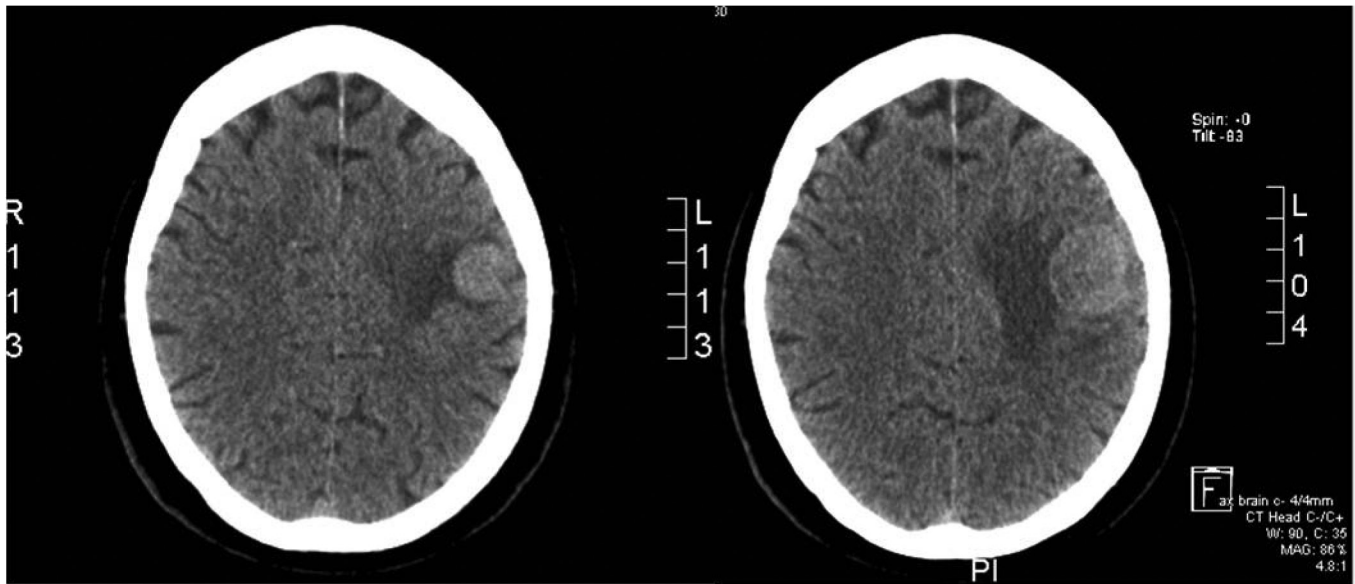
CT head comparing the size of the most lateral and largest of the two metastases performed one month apart. The original scan from the first admission (Left) and the scan from the current admission (Right) are shown.
